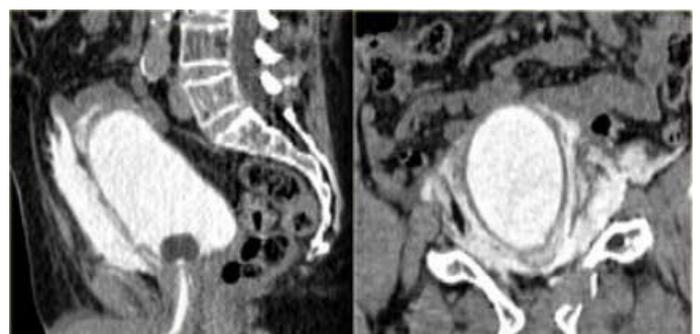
CT scan image showing injury to bowel
